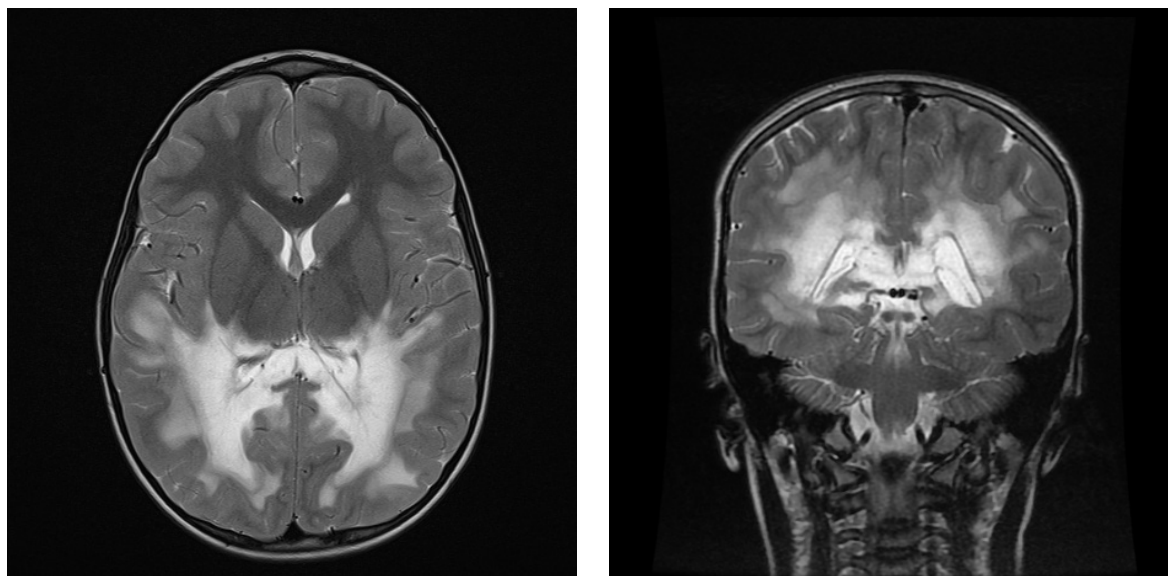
Patient's magnetic resonance imaging.
